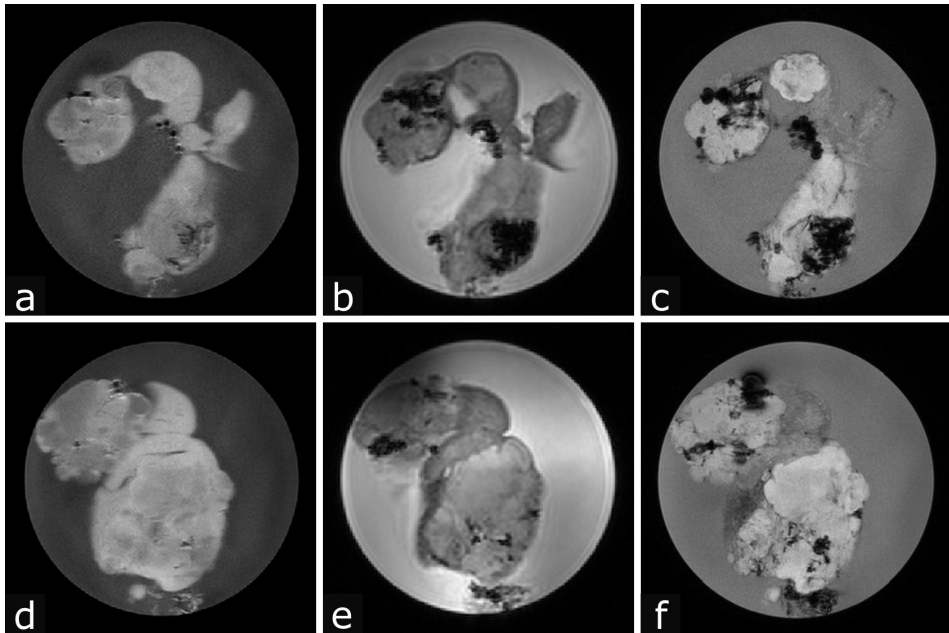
MR images of the *ex-vivo* liver. T_1 -weighted TSE, insensitive for holmium (a, d), 3D FFE (b, e), and T_2 -weighted mFFE (c, f), both of which are holmium-sensitive sequences, on which the holmium cluster of HoAcAcMS are visible as black artifacts
